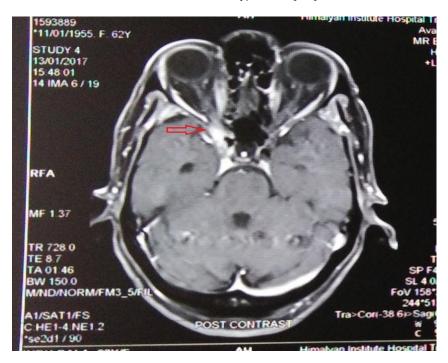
MRI brain showing soft tissue density at right optic foramen
